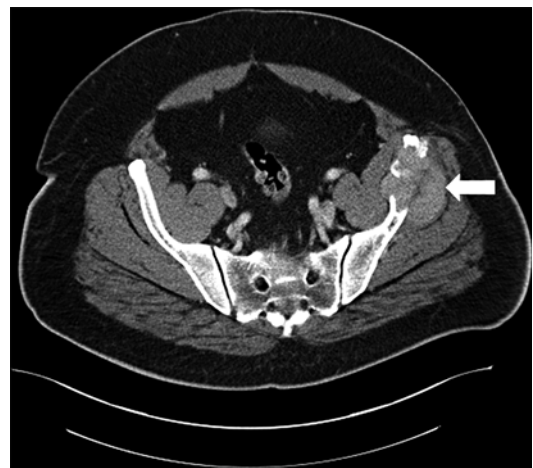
CT pelvis showing 6.2×8.1 cm left pelvic distant metastasis (arrow) of a papillary thyroid cancer in a 57-year-old male. Patient had total thyroidectomy revealing a 4 mm follicular variant papillary thyroid cancer
